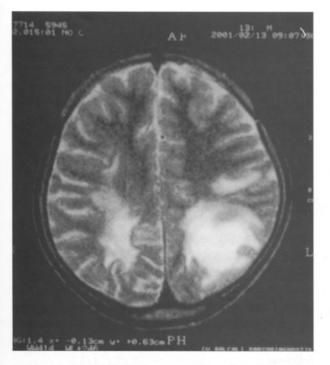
T-2 W MRI five years later showing a new lesion in the left posterior parietal lobe and right posterior parietal encephalomalasia.
